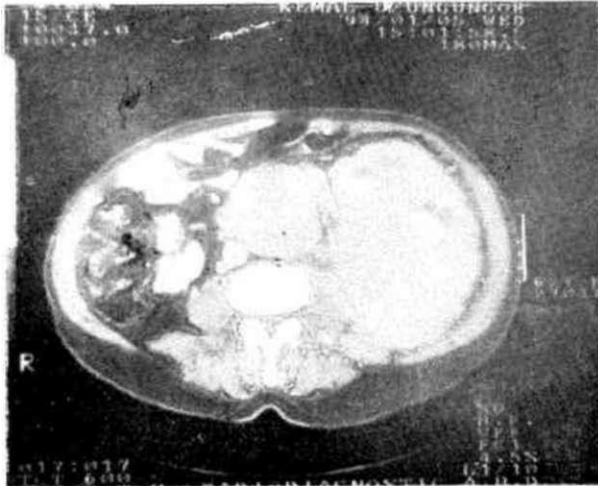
CT scans revealed a bulky mass that slightly enhanced after contrast in the middle and upper pole of the kidney and paraaortic lymphadenopathies
